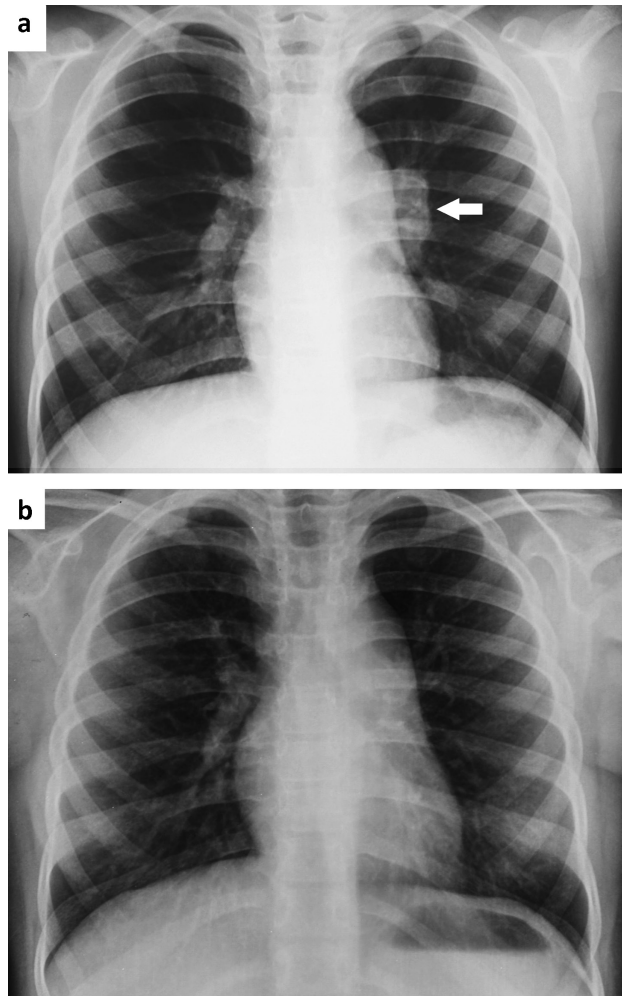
Chest X-ray. a) At presentation showing left hilar lymphadenopathy (arrow). b) Following resolution of left hilar prominence after 6 months of treatment.
